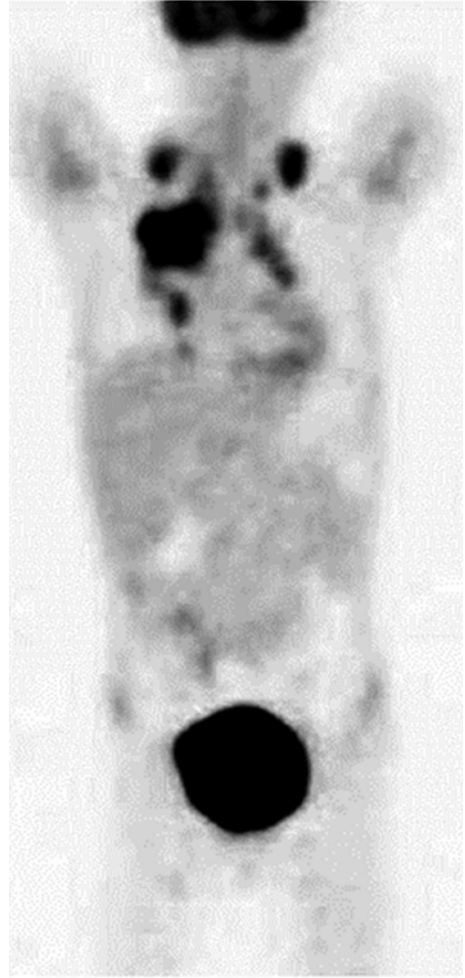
PET/CT scan detected the presence of nodal disease in cervical and supraclavicular area (SUVmax of 5,4) as well as extensive nodal disease in the mediastinum (SUVmax of 10.7)
